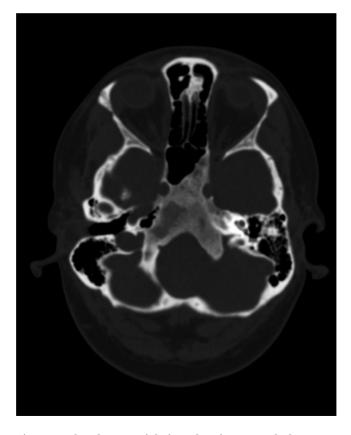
CT head scan axial view showing ground-glass appearance of the well-defined, expansile clival lesion.
